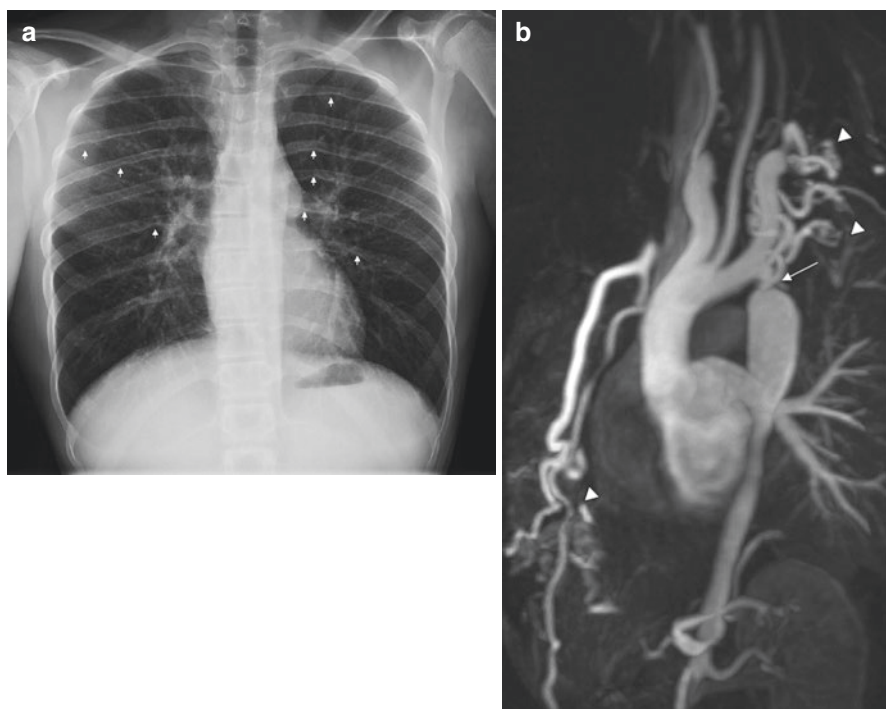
A 15-year-old male with hypertension and 20 mmHg gradient between the upper and lower extremity blood pressures. (a) Frontal radiograph shows notching of multiple ribs bilaterally (white arrows). (b) Oblique maximum intensity projection from 3D gadolinium MRA demonstrates aortic coarctation (white arrow) with multiple large collateral vessels (white arrowheads)
